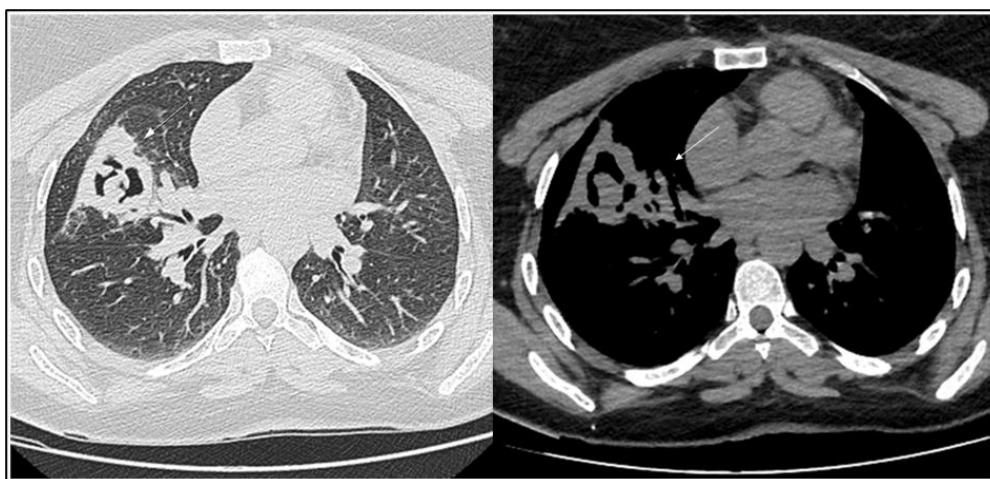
Chest computed tomography shows a right middle lobe cavitory lesion containing an intracavitary mass separated from the cavity wall by an air crescent
